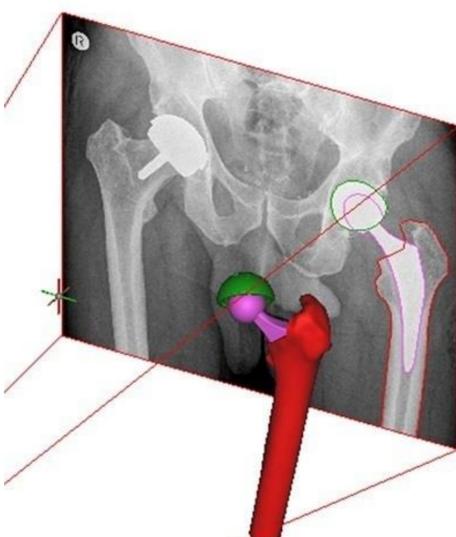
3D to 2D registration of the resected femur to the postoperative AP radiograph
